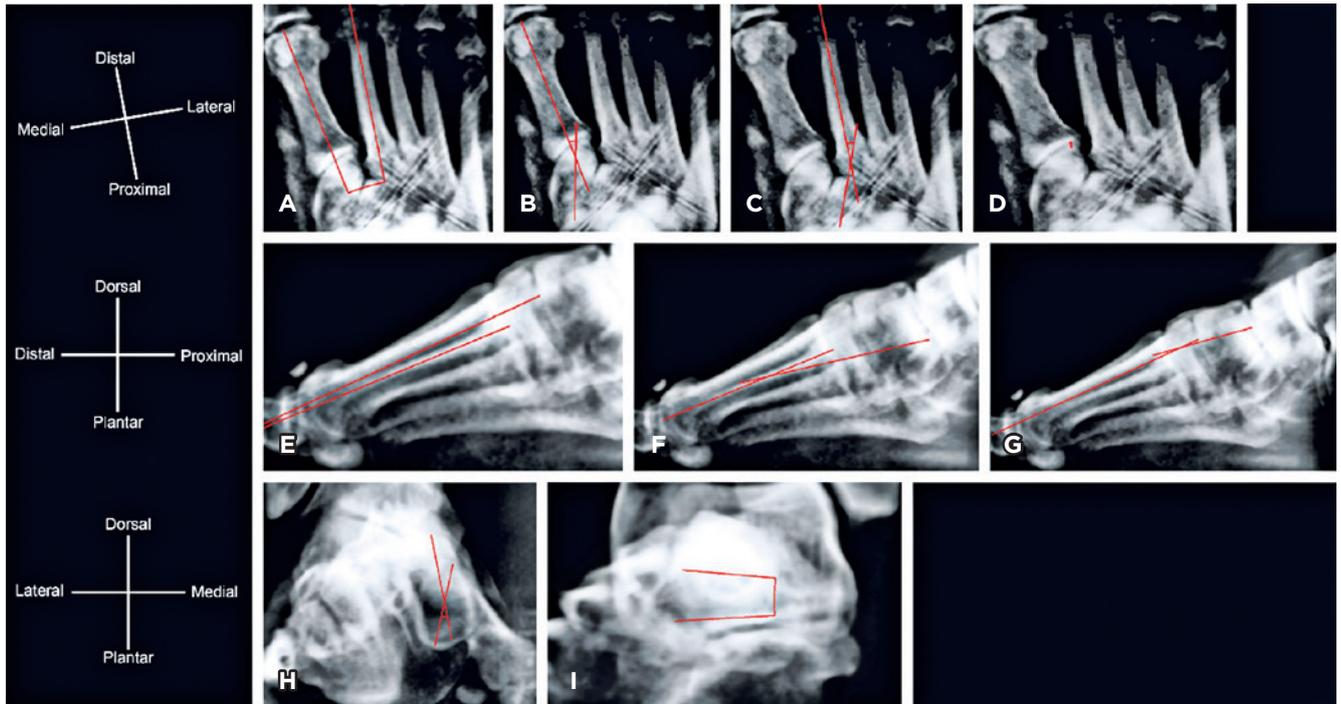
Digitally reconstructed radiographs from DISIOR showing the automatically calculated measures of (A) axial plane angle between the first and second metatarsal, (B) axial plane angle between the medial cuneiform and first metatarsal (first tarsometatarsal joint), (C) axial plane angle between the intermediate cuneiform and second metatarsal (second tarsometatarsal joint), (D) minimum joint space in the first tarsometatarsal joint, (E) sagittal plane angle between the first and second metatarsals, (F) sagittal plane angle of the first tarsometatarsal joint, (G) sagittal plane angle of the second tarsometatarsal joint, (H) first metatarsal torsion, and (I) first metatarsal internal rotation.
